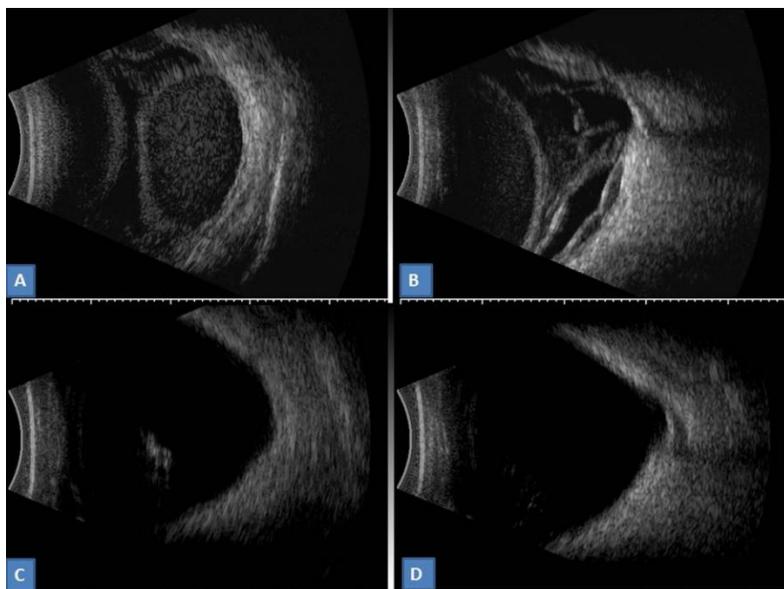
Image A and B are the preoperative B scan ultrasonography images of the right eye. Image A: showing the hemorrhagic choroidal detachment Image B: showing the haemorrhagic choroidal detachment with associated retinal detachment, vitreous hemorrhage and posterior staphyloma. Image C and D are post-operative scans showing the posterior staphyloma with mild residual vitreous hemorrhage. The choroidal and retinal detachments had resolved.
